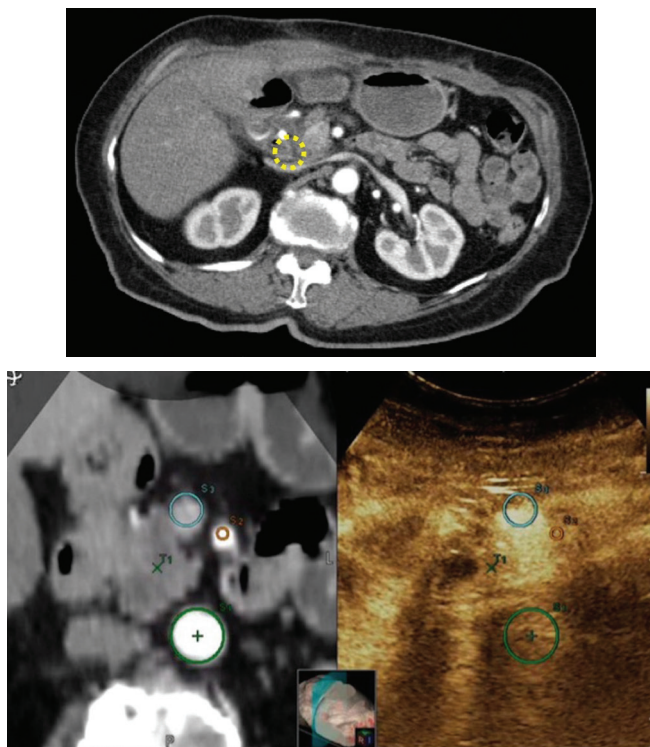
Stable total necrosis at CT (left) and RVS ultrasound (right) at 6 months after RFA ablation.
